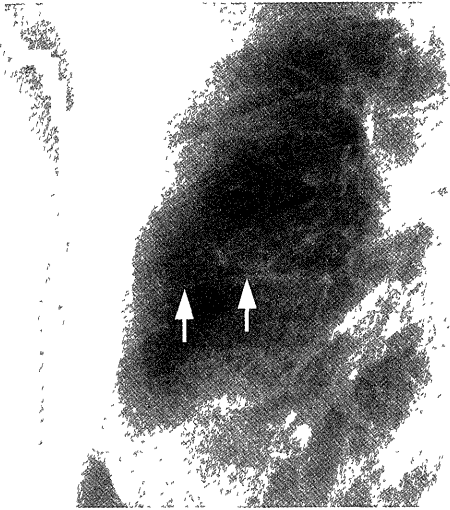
Superomedial major fissure. PA chest radiograph shows the superomedial major fissure on the right (arrow). Incidentally, the minor fissure is seen as double lines. (Reprinted with permission from Hayashi K et al. (10))
